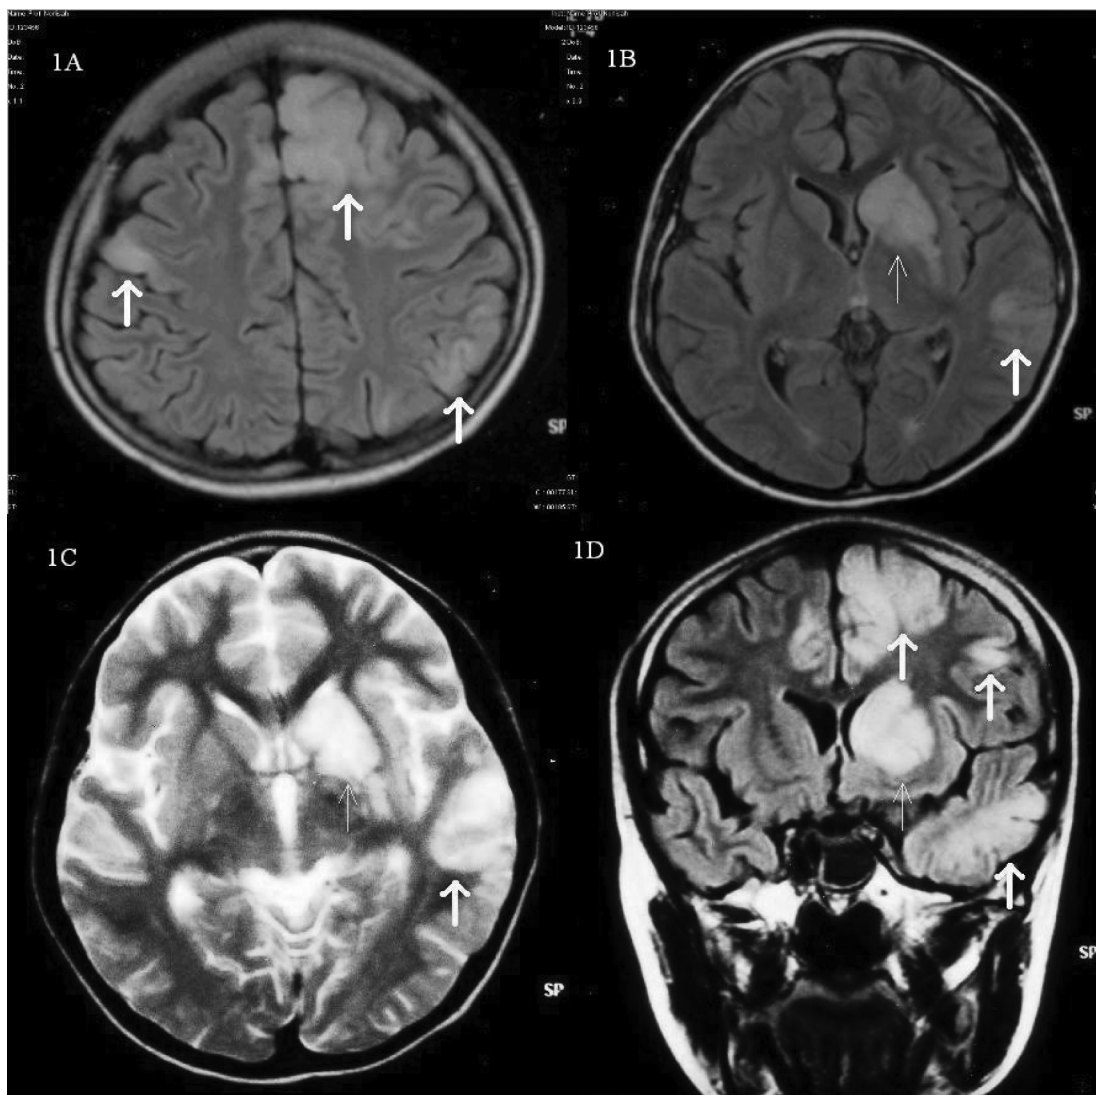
MRI FLAIR axial sequence (figure 1A and 1B), T2 weighted axial image (figure 1C) and FLAIR coronal sequence (figure 1D) showing confluent gray matter (thick arrows) and left caudate nucleus and putamen involvement (thin arrows).
